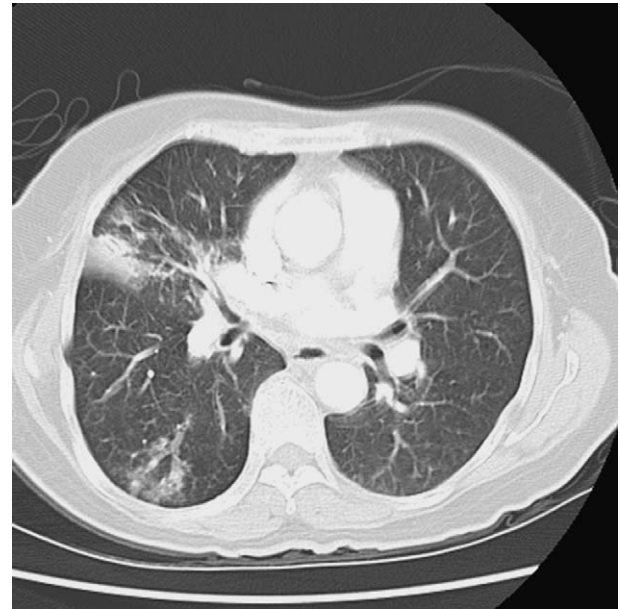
Thorax CT with LPC pattern.
